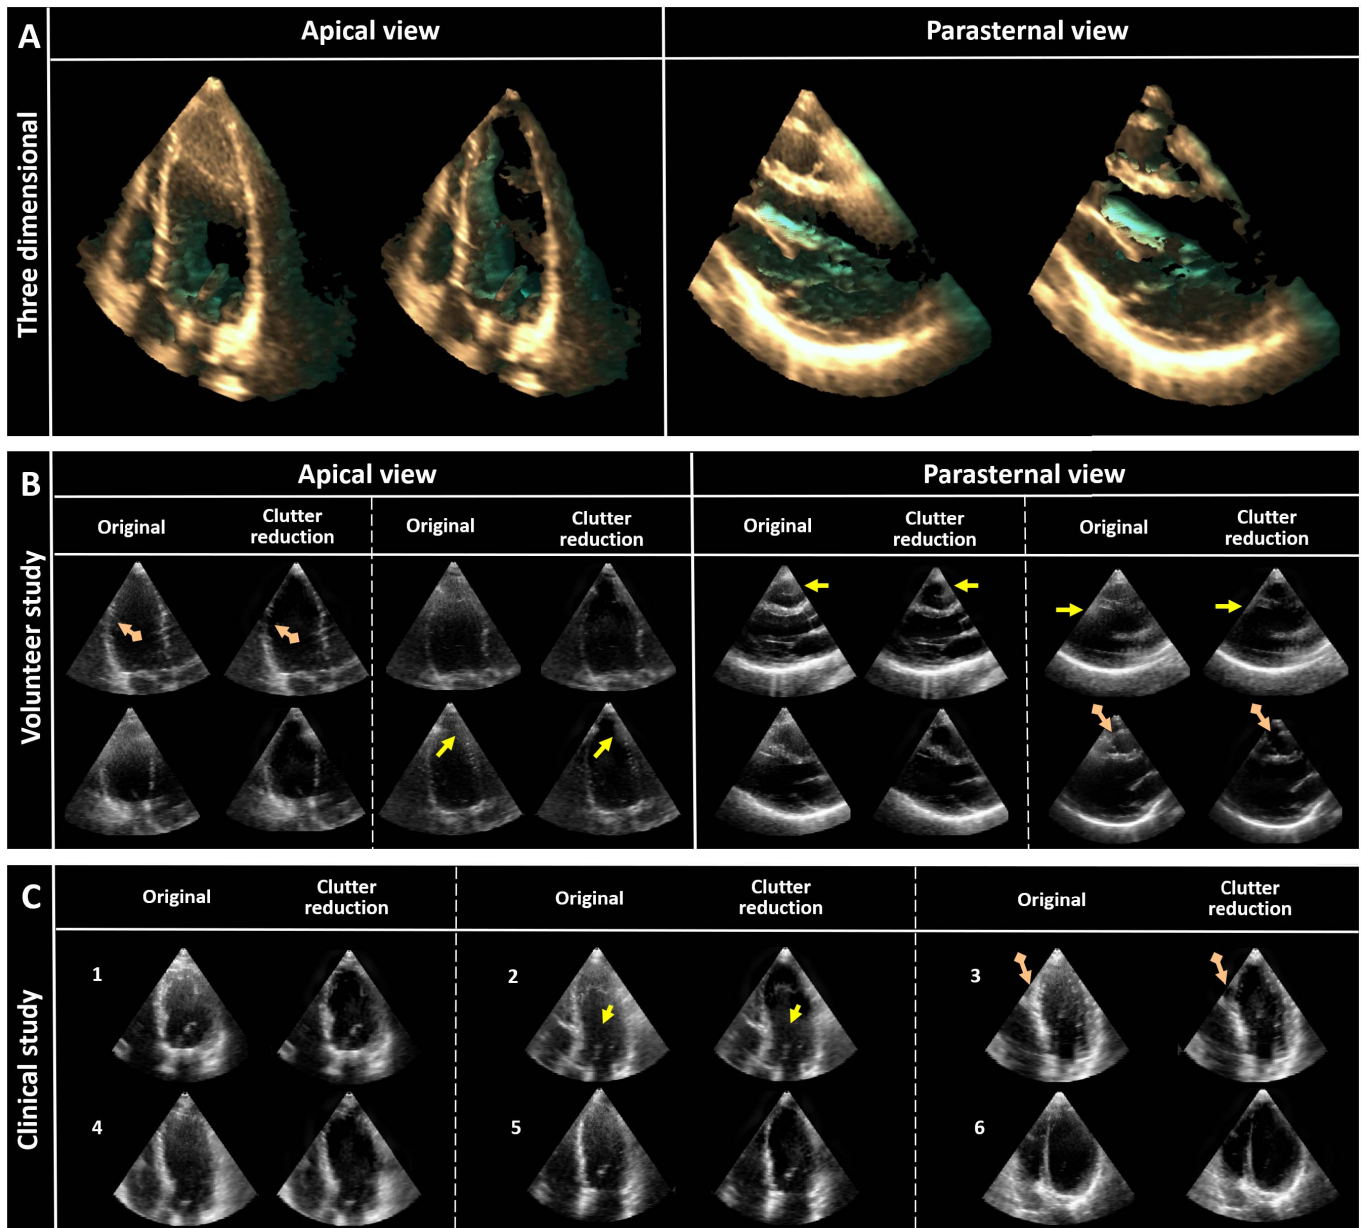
Representative images showing the results of the NF clutter reduction algorithm applied to (a) 3-D apical and parasternal volume, and 3-D images of (b) volunteer and (c) clinical acquisitions at end-diastole. (a) For clarity, only the middle section of the 3-D volume is shown. (b) and (c) Yellow arrows indicate regions where NF clutter elimination was incomplete. The orange arrows with the diamond-shaped ends point out regions where myocardial tissue was incorrectly removed or slightly reduced in intensity value. For every example, first the original image is shown, and to their right the NF clutter compressed result is depicted. Overall, almost all of the NF clutter was removed, whilst preserving the US speckles. (b) Four apical and four parasternal representative examples are shown. An overview of all acquisitions is shown in Fig. 9 included in the multimedia files. (c) For each of the included indications for echocardiography in this study, a representative example is shown. The indications were: 1) valvular heart disease; 2) coronary artery disease; 3) hypertensive cardiomyopathy; 4) chest pain assessment; 5) heart rhythm disorder; and 6) cardiac sarcoidosis. In Fig. 10 included in the multimedia files, the results of all acquisitions can be found.
